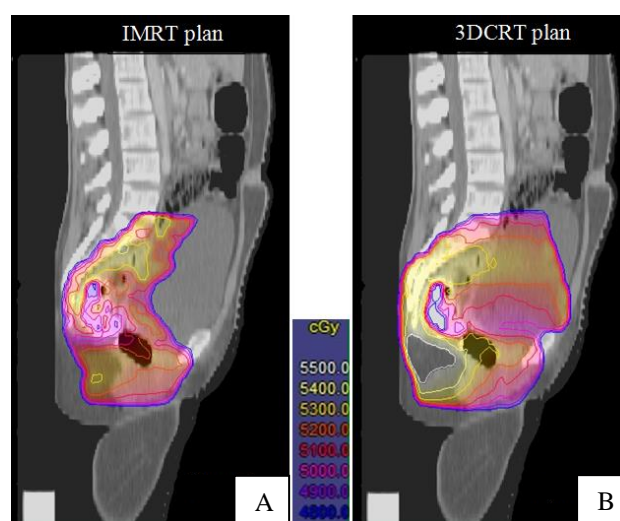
Dose distribution in sagittal CT slices of same patient being planned for IMRT and 3DCRT respectively.
